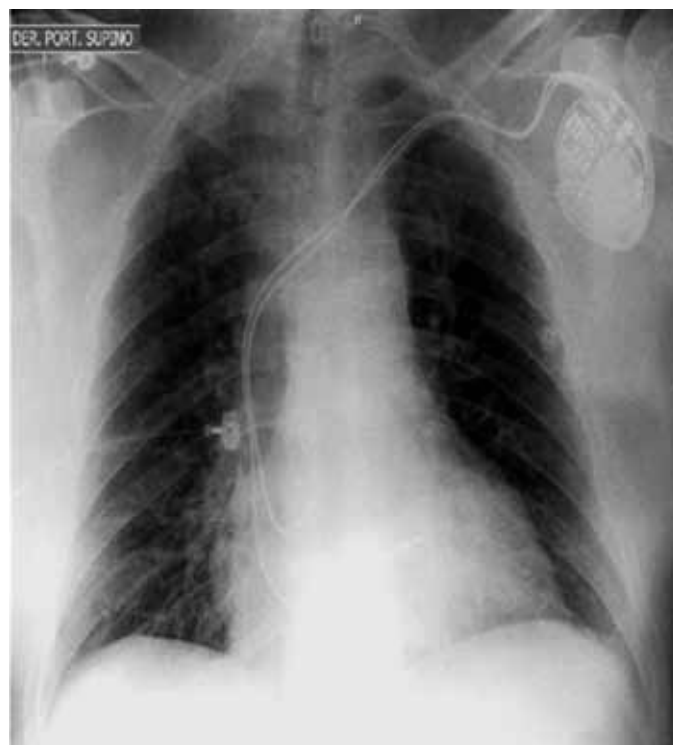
Chest X-ray after pacemaker implantation.
